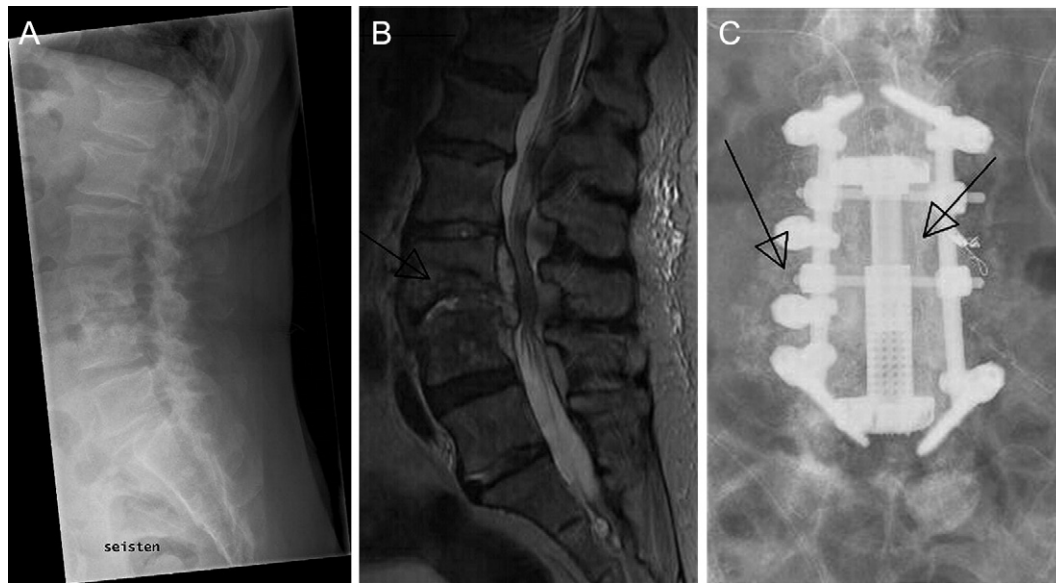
(A–C) Osteomyelitis caused by *Mycobacterium tuberculosis* in the spine treated with BAG-S53P4 as bone graft substitute: (A) preoperative X-ray and (B) MRI scan showing abscess formation in L III (arrow) and (C) postoperative X-ray showing implant covered with BAG-S53P4 (arrow).
